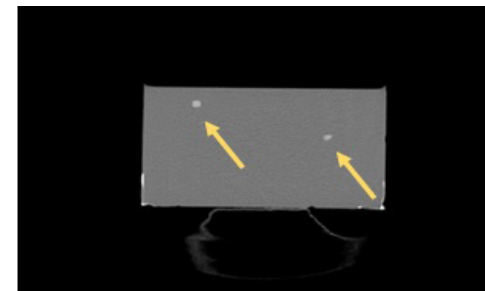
CT of the model. The dental filling material.
